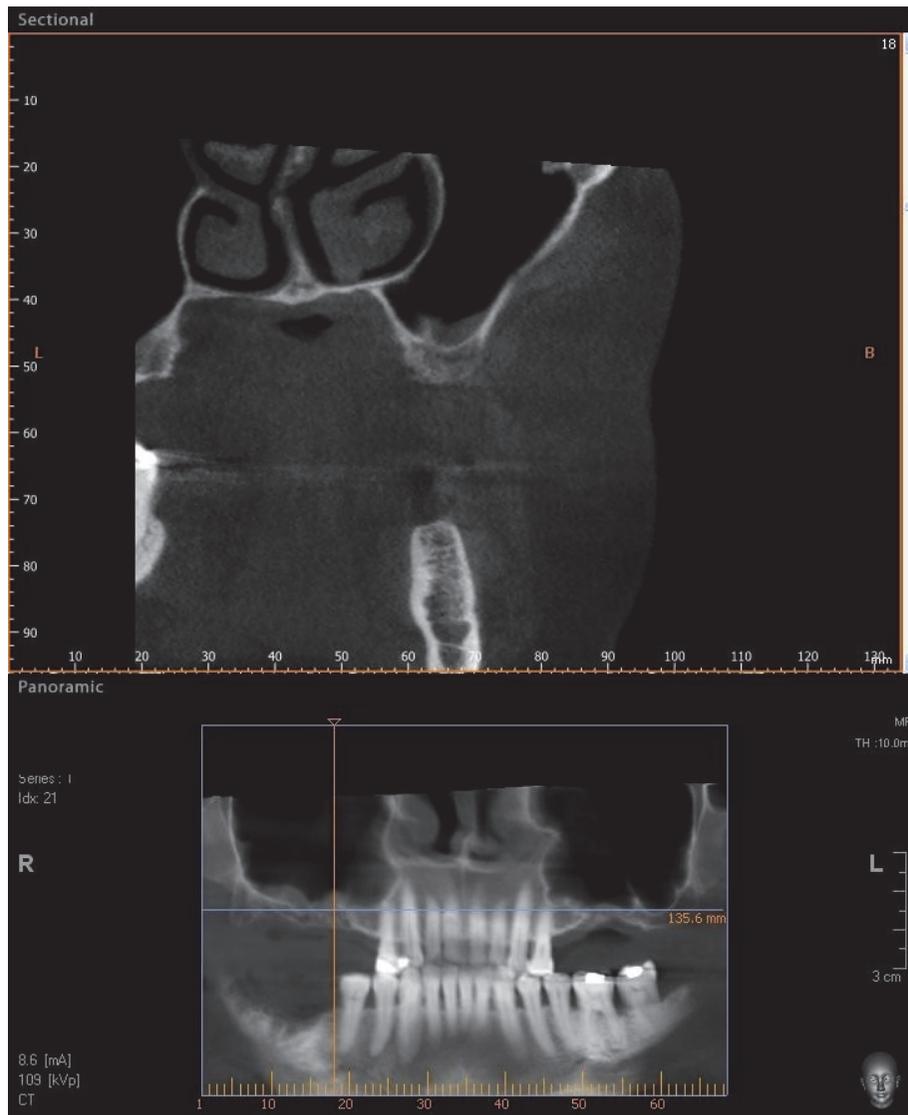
CBCT of an edentulous patient with bilateral severely atrophic maxilla.
